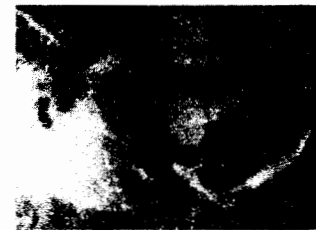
Case 1—Pre-operative X-ray view of ankylosed left mandibular joint.
